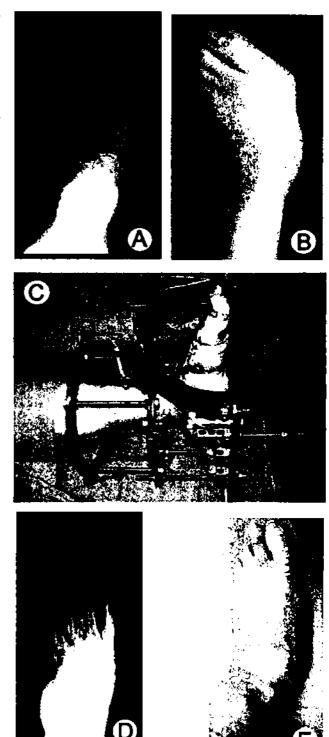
Severe midfoot collapse due to Charcot neuroarthropathy as shown (A) on radiograph and (B) in clinical presentation. (C) This patient was treated with tarsometatarsal arthrodesis using a multiplanar circular external fixator. (D) A postoperative radiograph and (E) clinical photograph at 4 months postoperative are shown here.
